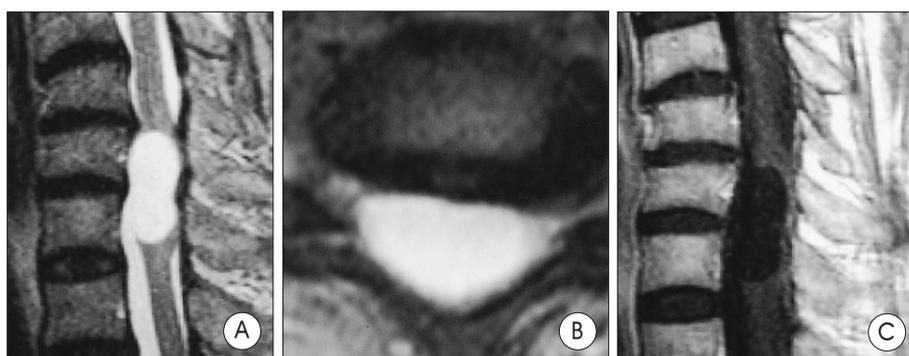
Preoperative spin echo sagittal(A), axial(B) T2 weighted magnetic resonance(MR) image, and postcontrast sagittal(C) T1 weighted magnetic resonance image showing C6–C7 intramedullary cystic lesion which locates ventrally to the spinal cord and compresses the spinal cord. There is no enhancing part of cystic lesion. Bony, soft tissue abnormalities are not seen.
